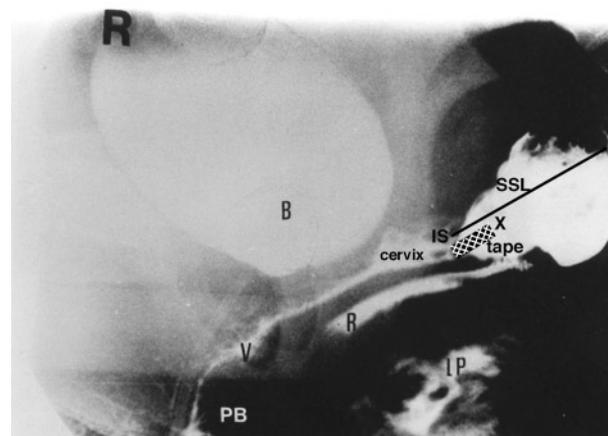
Xray of a nulliparous patient, resting sitting position. Note that the cervix is situated just below the level of the ischial spine. X marks the penetration point of the tunneller just medial and behind the ischial spine (IS). SSL=sacrospinous ligament; LP=levator plate; V=vagina; R=rectum; PB=perineal body; B=bladder. The tape and line of SSL have been superimposed on the original xray.
